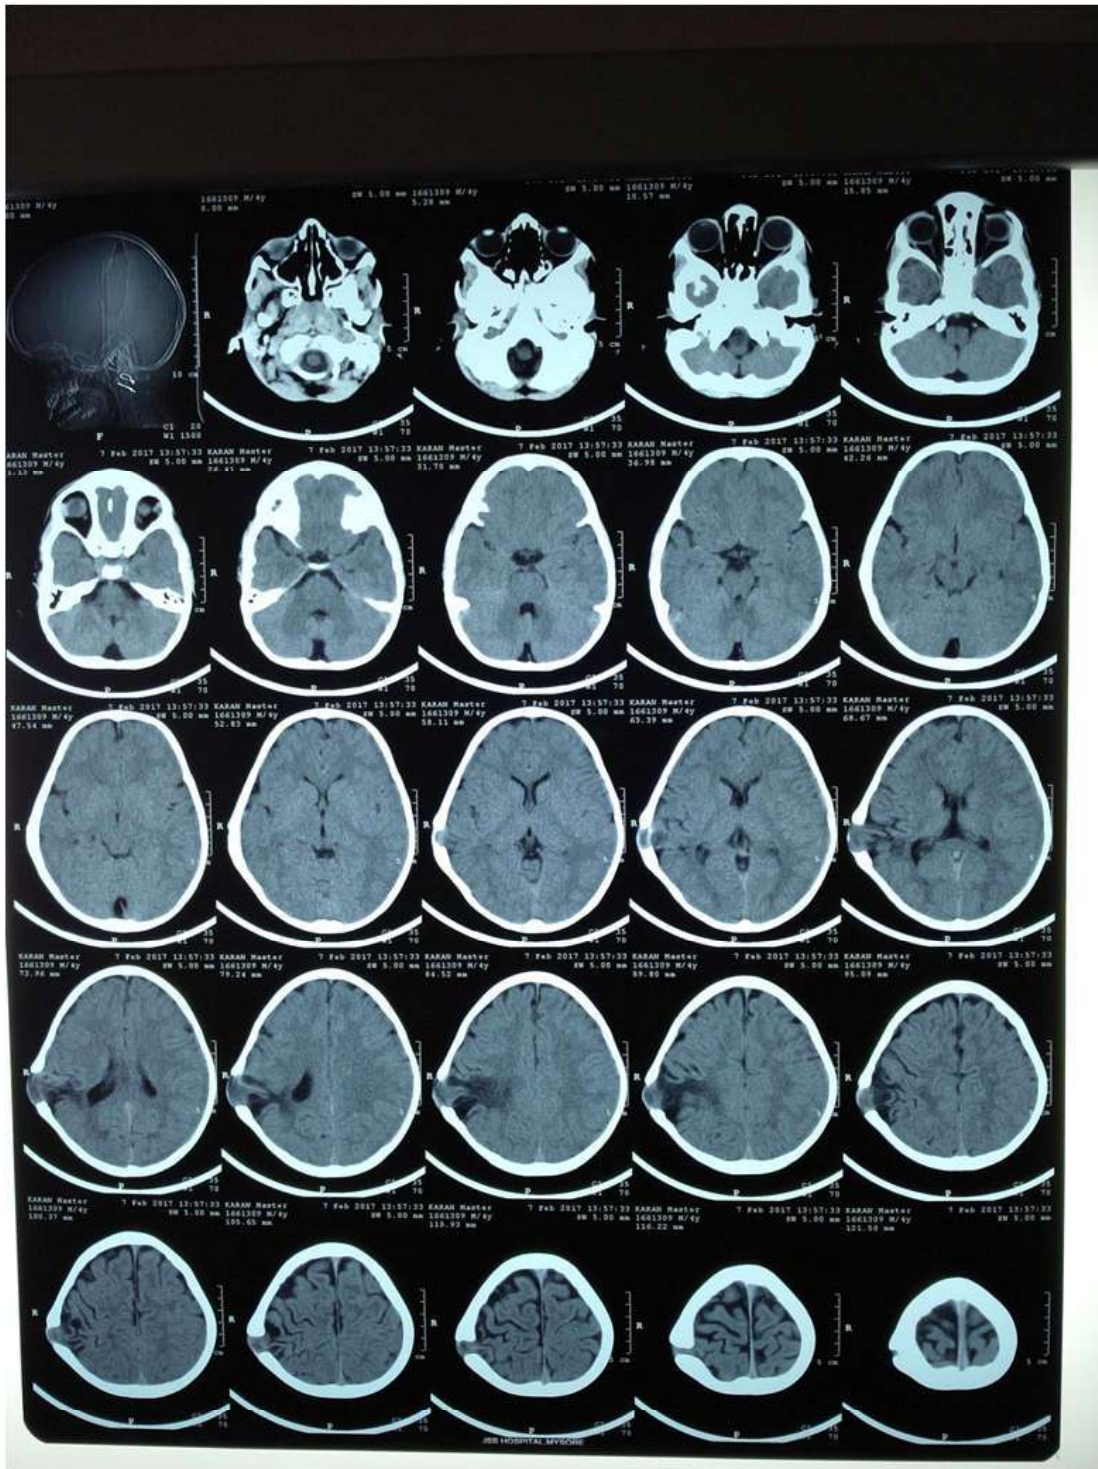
CT brain showing lytic calvarial defect with scalloped edges seen in right parietal bone with maximum width being 24mm and length being 90mm with extracranial brain herniation through it. Adjacent brain parenchyma showed encephalomalacic changes.
